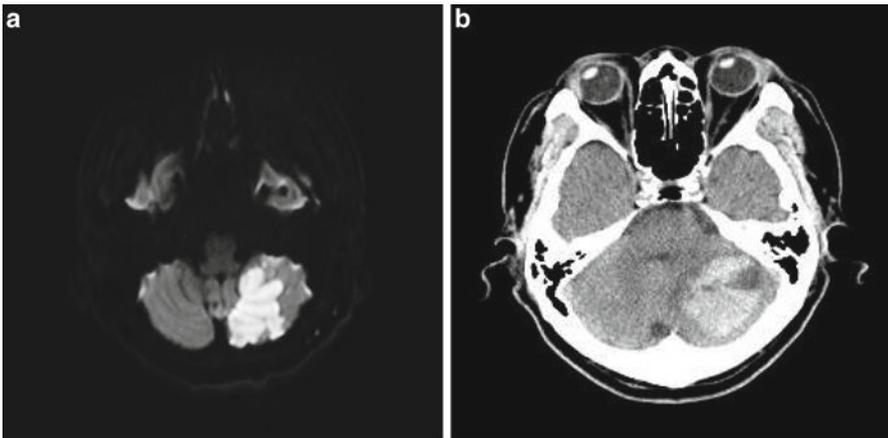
Type of cerebellar stroke. Cerebellar stroke consists of cerebellar infarction and hemorrhage. Diffusion-weighted magnetic resonance image demonstrates cerebellar infarction in the left PICA territory (a). Brain CT (b) shows hemorrhage in the left cerebellar hemisphere
